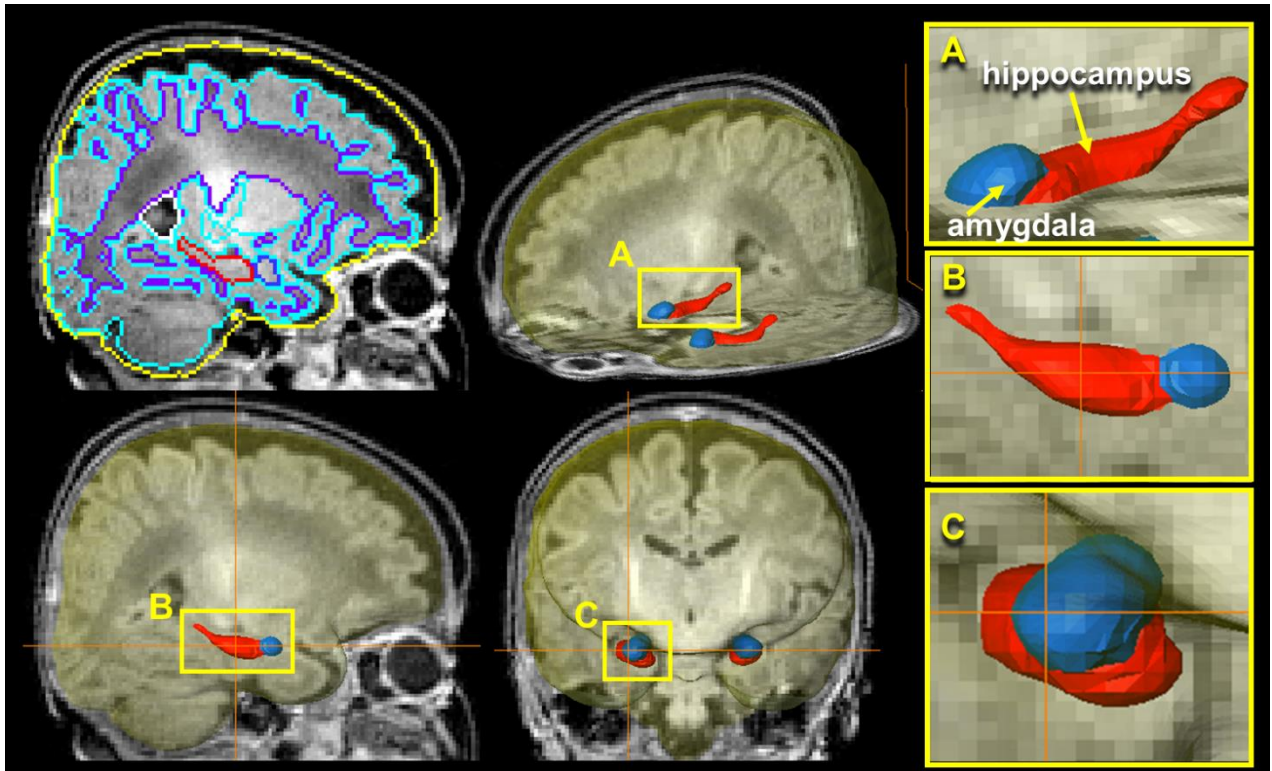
Automated segmentation of brain structures, showing the total gray matter (green outline), the total brain volume (yellow outline), and the total intracranial volume (transparent yellow overlay on MRI), the hippocampus (red) and amygdala (turquoise color), on a T1-weighted MRI scan from a neonate. The inlays A, B and C show enlarged versions of hippocampus and amygdala for better visualization.
